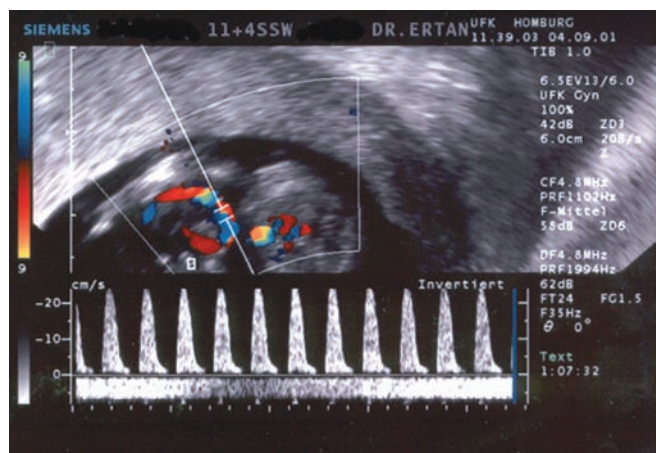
Doppler velocity waveforms of umbilical artery (end-diastolic zero flow) and continuous venous blood flow of umbilical vein in 11+4 weeks of pregnancy.
